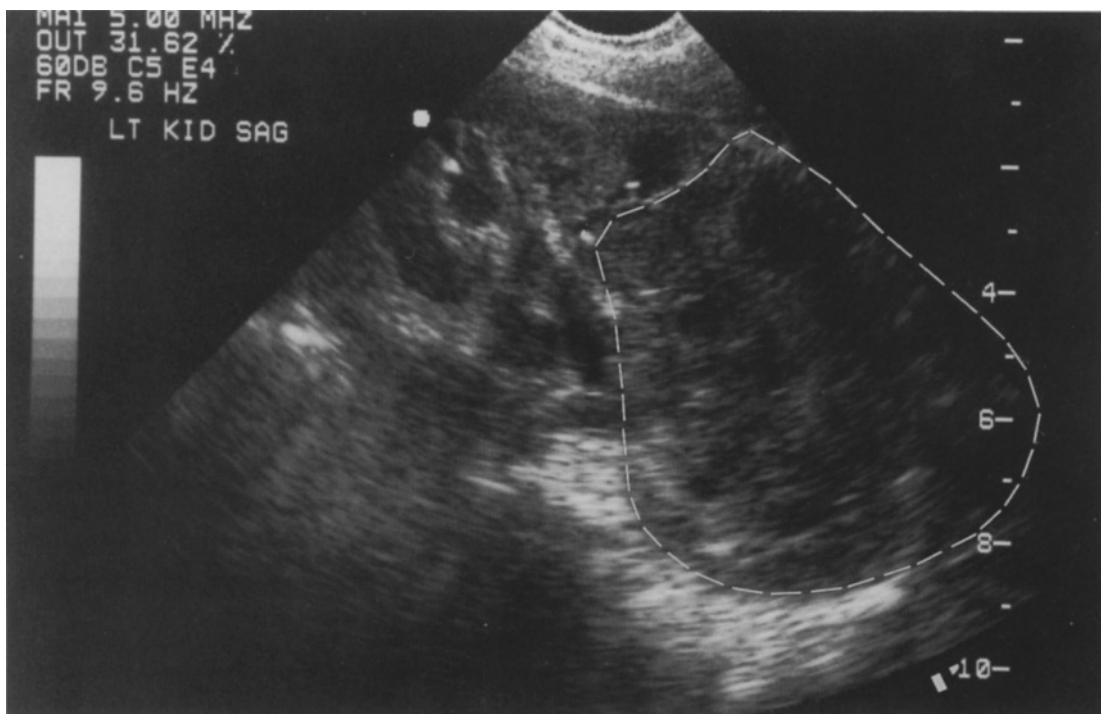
Sagittal ultrasound of the left kidney demonstrates a large, solid, inhomogeneous mass (encircled) arising from the lower pole.
